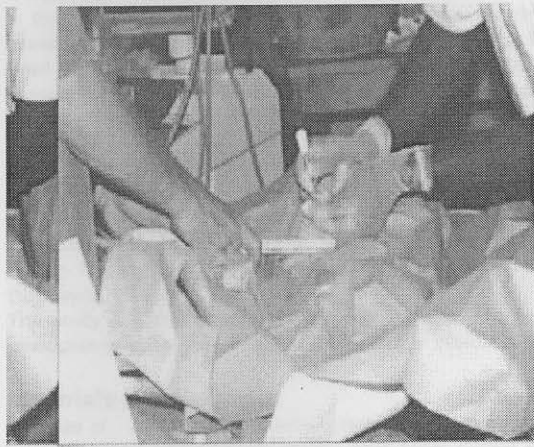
Puncture of *Echinococcus* cyst under ultrasound guidance
